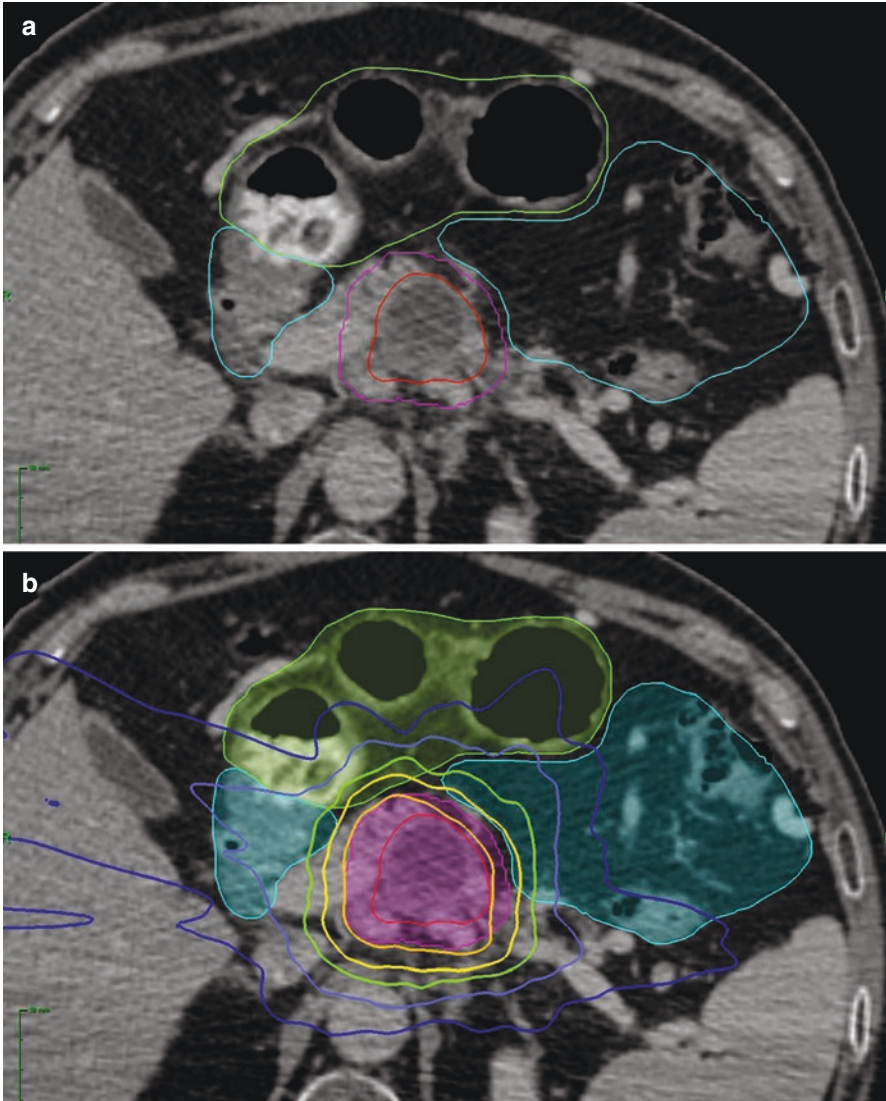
A patient with unresectable pancreatic adenocarcinoma treated with SBRT using CyberKnife, prescribed 30 Gy in three fractions, an ideal SBRT candidate due to distance and dose fall off between duodenum and tumor. (a) Delineation on contrast-enhanced CT of the hypo-enhancing GTV (red) with a PTV expansion (purple) covering the posterior tumor-vessel interface and celiac artery. The bowel contour is shown in blue and stomach in green. (b) Target and organs are shown shaded with doses displayed as lines, orange, 30 Gy; yellow, 20 Gy; green, 15 Gy; light blue, 10 Gy; dark blue, 5 Gy (Note the 30 Gy isodose curve covers the entire GTV but not the PTV to minimize the bowel dose)
